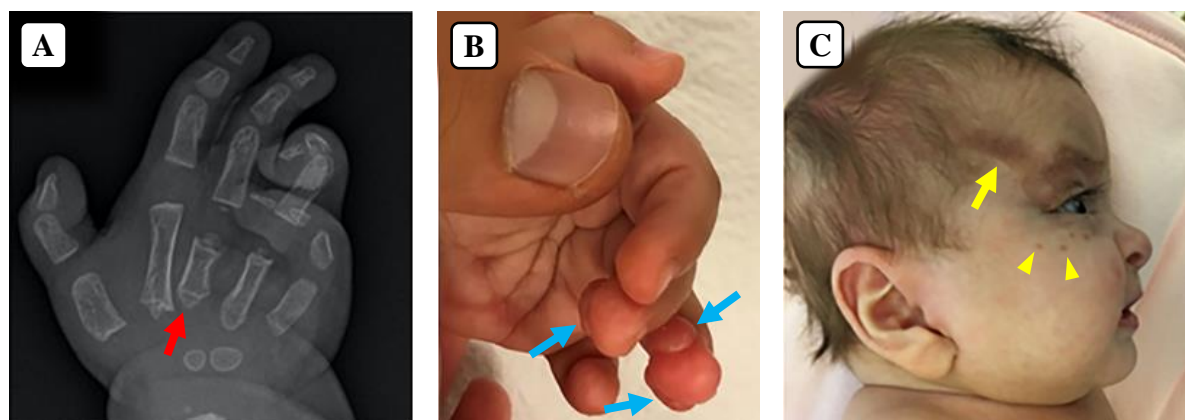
Clinical features of DCD. Triad of skeletal dysplasia, digital fibromatosis, and skin defects typical of DCD. (A) Hand radiograph showing a malformed metacarpal (red arrow). (B) Digital fibromata on the lateral aspects of the tips of the third and fourth digits (blue arrows). (C) Hyperpigmented atrophic lesion in the temporal region lateral to the eyebrow (yellow arrow) along with depressed hyperpigmented spots on the cheek (yellow arrowheads).
